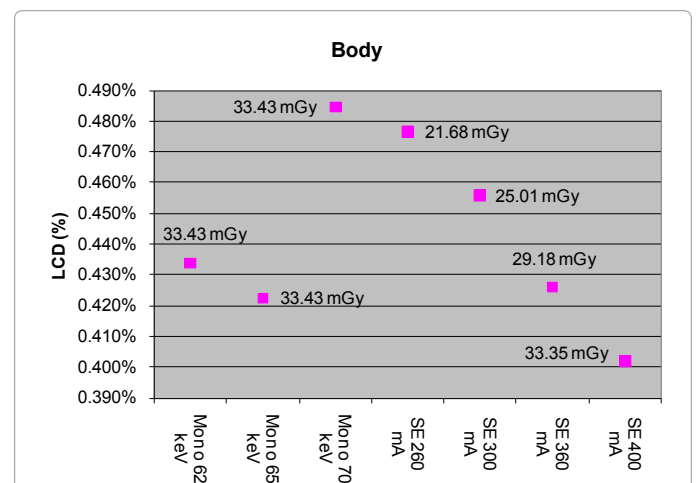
Comparison of the measured CTDI_{vol} (in mGy) between a FKS dual-energy and routine (i.e., single-energy) abdominal CT exams as a function of monochromatic energy (in keV, dual-energy only) and tube current (in mA, single-energy only) (All other acquisition protocols were the same between the two systems compared: kVp=120 kVp, gantry rotate speed=1.0 s, bowtie=large body, slice thickness=5 mm, display field of view=22.5 cm). The single-energy (SE) measurements are denoted as “SE xxx mA”, where “xxx” describes the tube current, while the dual-energy measurements are denoted as “Mono xx keV”, where “xx” represents the monochromatic energy (monochromatic energy will be discussed later in Section 3.3). Image adapted from Li et. al, Med. Phys. 38(5), 2595-2601 (2011).
